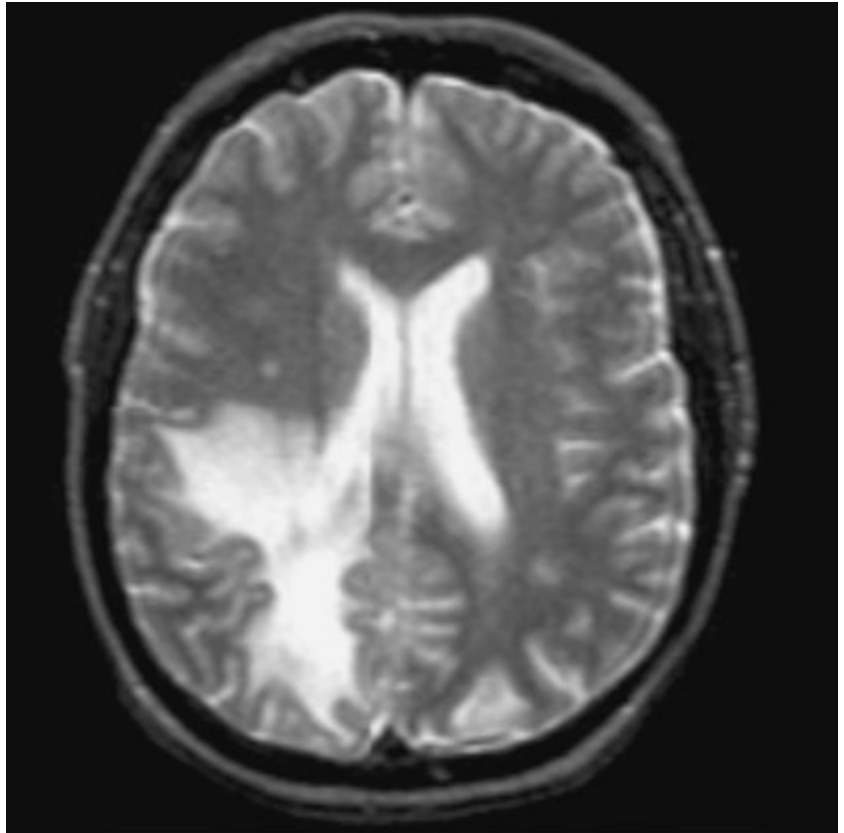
T2-weighted image shows large area of oedema following treatment.
